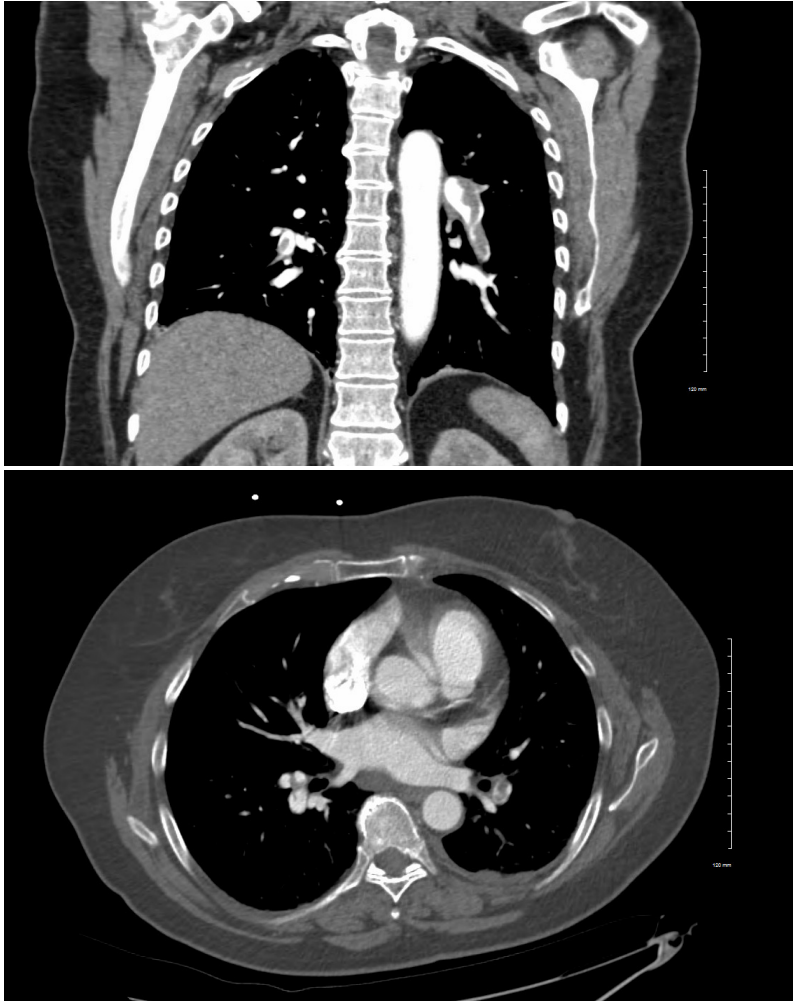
CT scan showing a newly developed Pulmonary Embolism in the Left Pulmonary Artery
